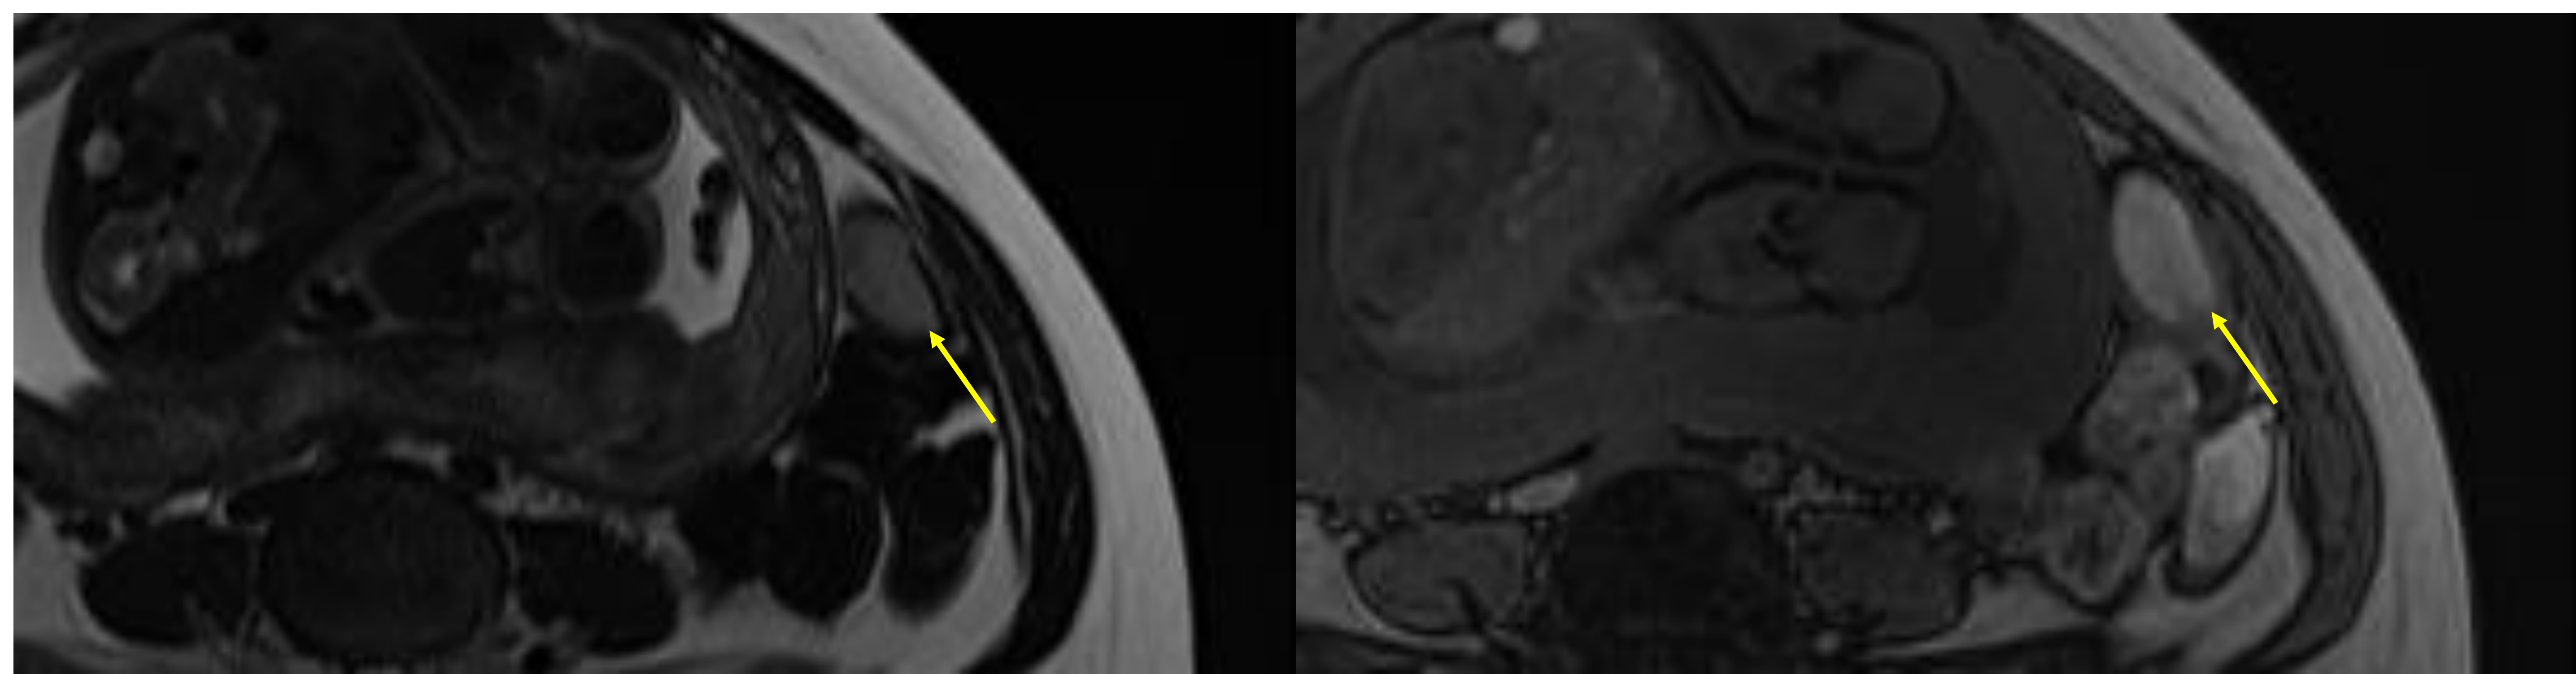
MRI image of pelvis, 2.7cm sized T1 and T2 high signal cystic lesion
